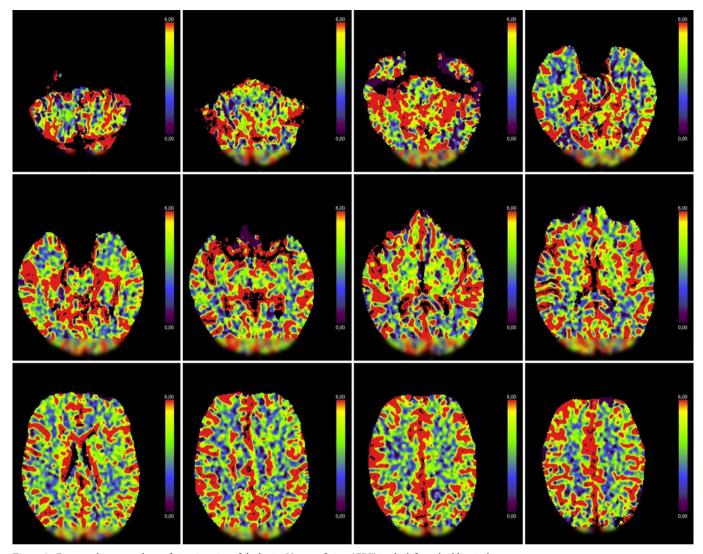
Computed tomography perfusion imaging of the brain: Hypoperfusion (CBF) in the left cerebral hemisphere.
